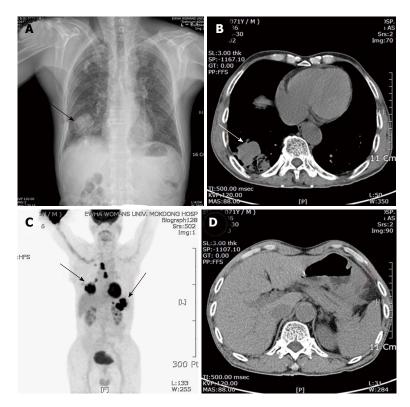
Chest posteroanterior view, computed tomography scan and [¹⁸F] fluoro-2-deoxy-*D*-glucose positron emission tomography-computed tomography. A: A solitary mass with solid opacity in the right lower lung (RLL) (arrow); B: Chest computed tomography (CT) scan demonstrated an irregular mass measuring 5.8 cm in size with central necrosis at RLL (arrow); C: [¹⁸F] fluoro-2-deoxy-*D*-glucose-positron emission tomography (FDG-PET)/CT showed a FDG-avid mass on the right lower lobe, mediastinum, stomach and splenic hilum; D: Abdominal CT showed an encircling mass at the body of the stomach with multiple enlarged perigastric lymph nodes and splenic hilar invasion.
